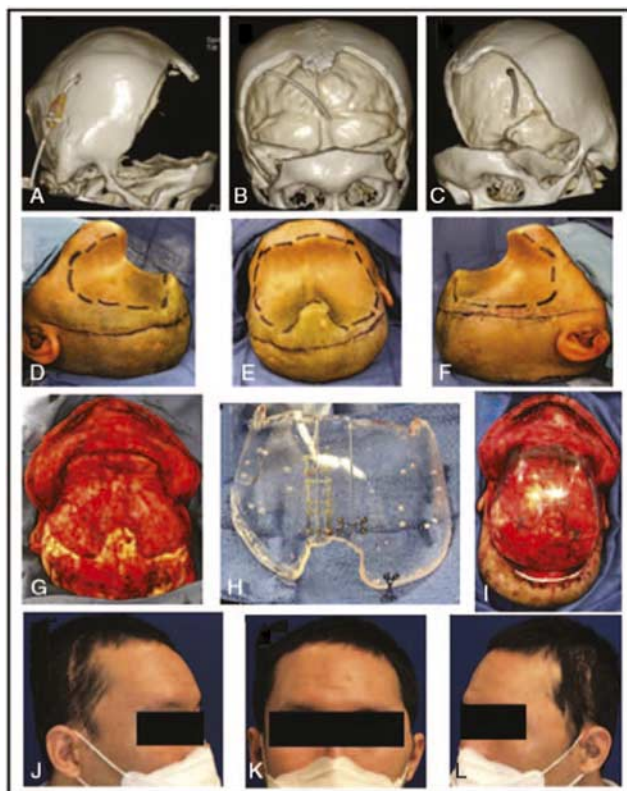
Representative photographs and CT scan images of a Neuroplastic Surgery patient who underwent reconstruction of a bifrontal craniectomy using clear PMMA implant. This is a 30-year-old male who was involved in a motor vehicle collision, sustaining a traumatic brain injury for which he underwent bifrontal craniectomy. His course was complicated by hydrocephalus for which a ventriculoperitoneal shunt was placed. He also had syndrome of the trephined with slowed speech and difficulty performing activities of daily living, with significant improvement after cranioplasty. (A-C) Lateral, frontal and oblique 3D-CT scan images showing craniectomy defect. (D-F) On table preoperative photographs showing the palpable craniectomy defect (dashed line), and the scar from his previous surgery (solid line). (G-I) Intraoperative photographs showing pericranial onlay dissection (G); customized clear PMMA implant, which was made in 2 segments and secured together with titanium plates and screws, then preplaced on the back table (H); and implant in place, prior to scalp closure (I). (J-L) Postoperative photographs demonstrating restoration of cranial contour. 3D-CT, three-dimensional computed tomography; PMMA, polymethyl methacrylate.
